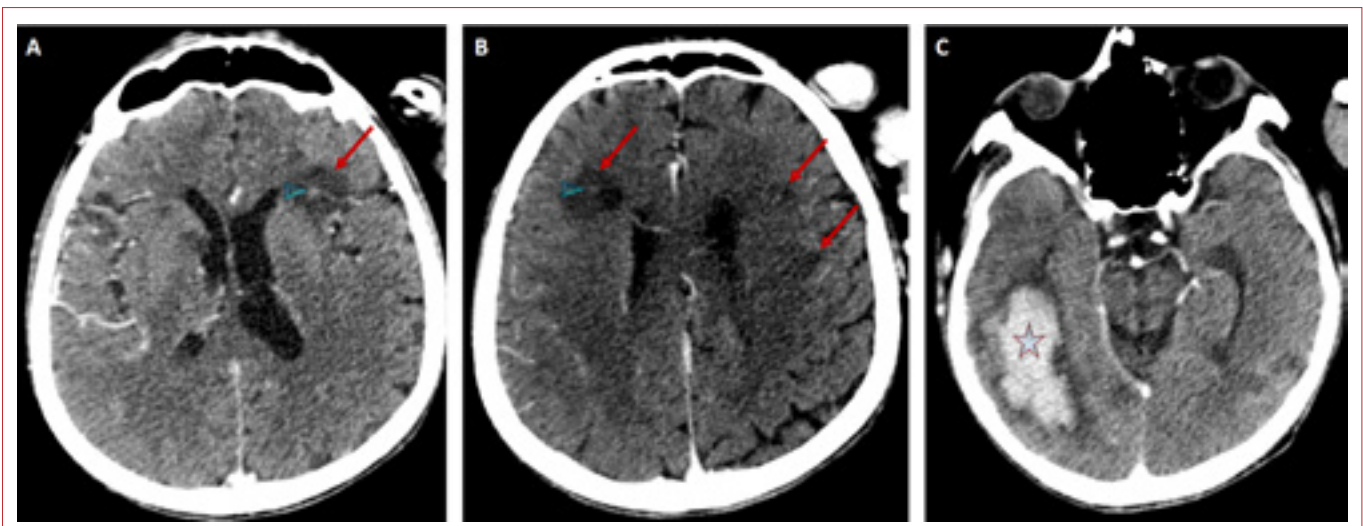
(a-c). Post-contrast consecutive axial CT scans (A and B) revealing multiple hypodense lesions (arrows) with a central vascular sign (arrow heads). The axial CT scan (C) from the brain stem level shows right temporal intraparenchymal hemorrhage (star).
